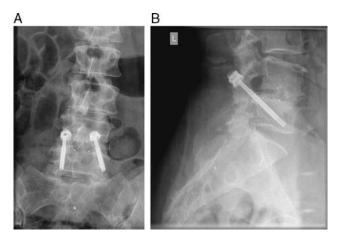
Case 2: Postoperative radiograph showing L4–5 interbody fusion on (A) anteroposterior and (B) lateral views.
